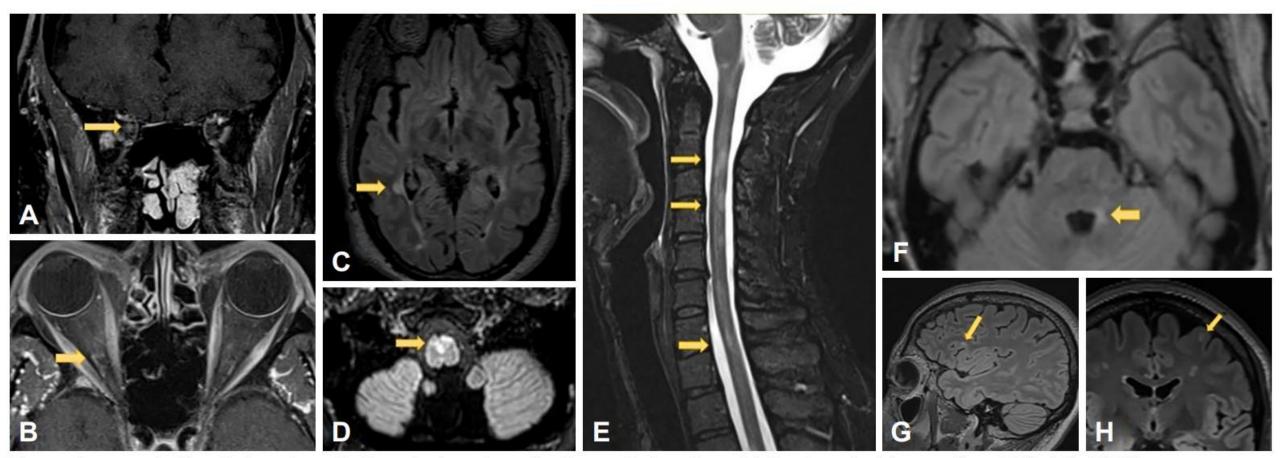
Juxtacortical/cortical, periventricular, spinal cord, and brainstem lesions in multiple sclerosis. A (coronal) and B (axial): MRI T1-post contrast images show enhancement in the intraorbital segment of the optic nerve consistent with right optic neuritis (arrows). C: Right posterior periventricular lesion on axial T2-FLAIR (arrow). D: Ventral medullary demyelinating lesion on T2-FLAIR (arrow). E: MR cervical cord sagittal STIR demonstrating C2-3, C4, and C7 demyelinating lesions (arrows). F: Axial T2-FLAIR with demyelinating lesion in left brachium pontis (arrow). G (sagittal) and H (axial): T2-FLAIR images demonstrate left frontal juxtacortical demyelinating lesion (arrows). J Clin Neurol 2023;19(3):217-229
